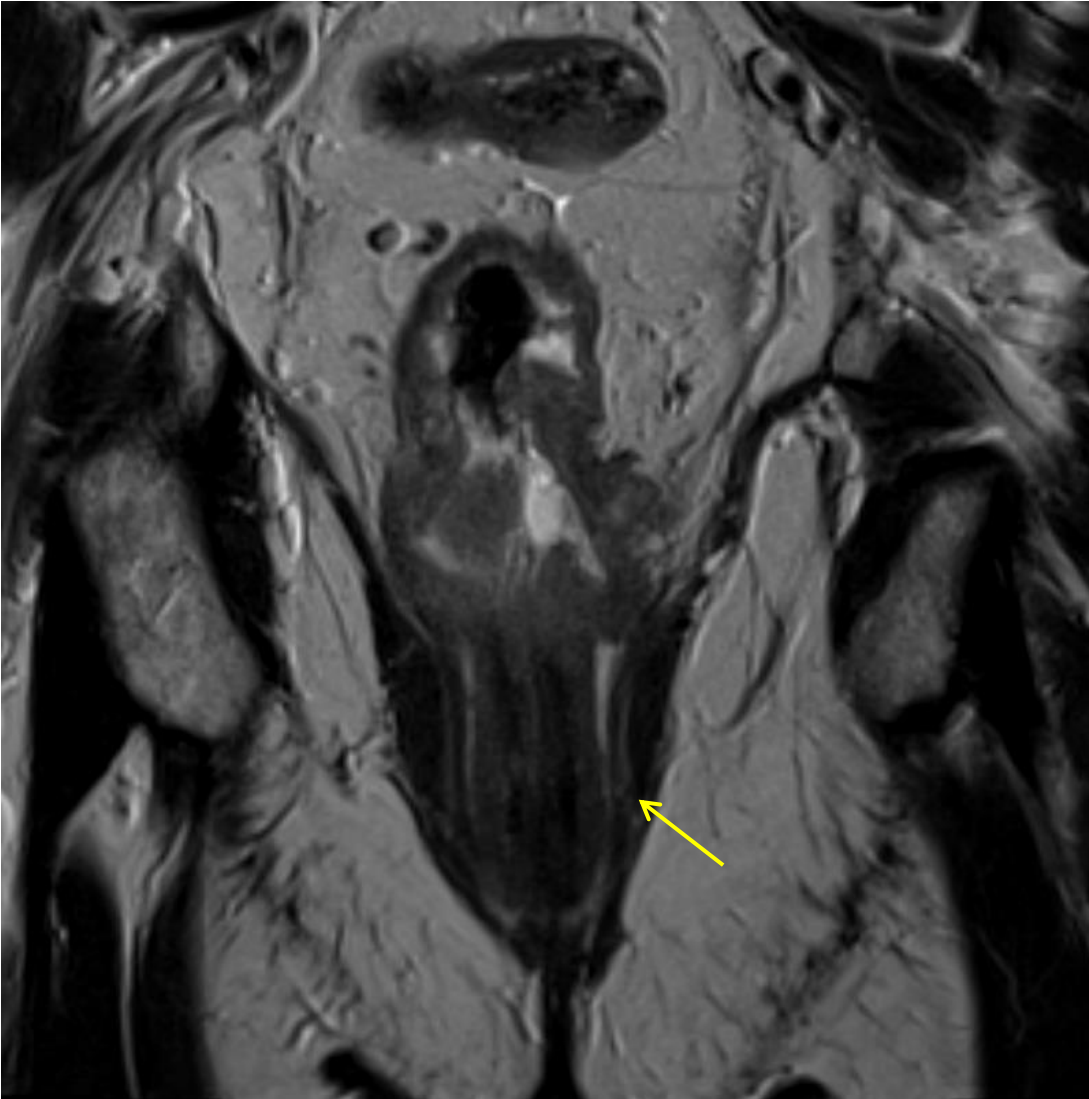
(Case 143) Coronal and sagittal MRI images of a 62-year old male patient with a locally advanced lower rectal cancer staged cT3N1b with circumferential margin invasion (infiltration shown by the yellow arrow) and invasion of the intersphincter space.
